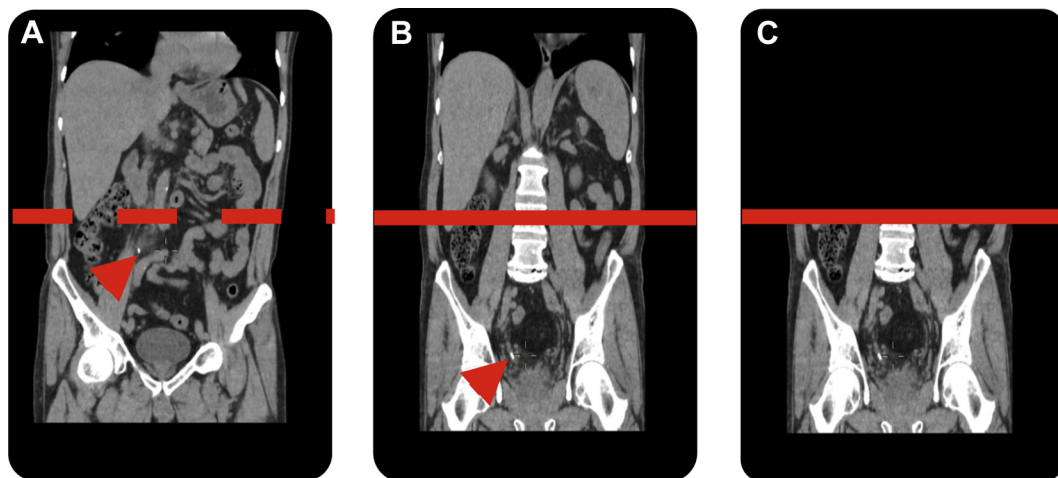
A, diagnostic CT shows ureteral stone (arrow). Dotted line indicates upper limit of batch images. B, second full followup CT in same patient shows ureteral stone (arrow) distal to prior location. Line indicates upper batch limit. C, batch images form limited field CT, comprising images from second CT according to stone site on diagnostic CT (A).
